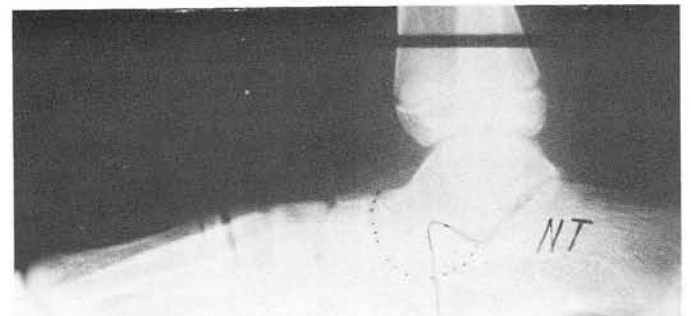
D. Lateral 2 1/2 year postoperative radiograph.
